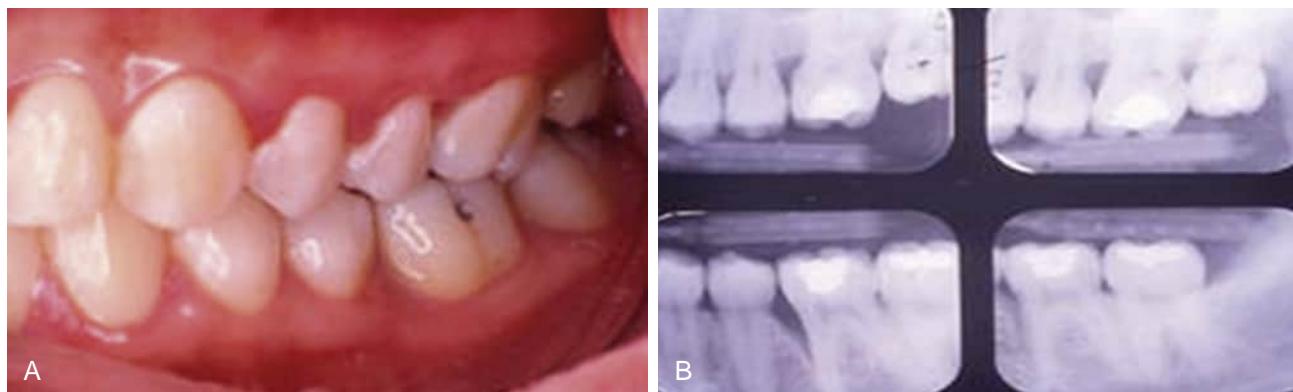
(A) Localized periodontitis-Molar-Incisor Distribution. (B) Radiographic evidence of vertical bone loss on the mesial surfaces of tooth #14 and especially tooth #19.
